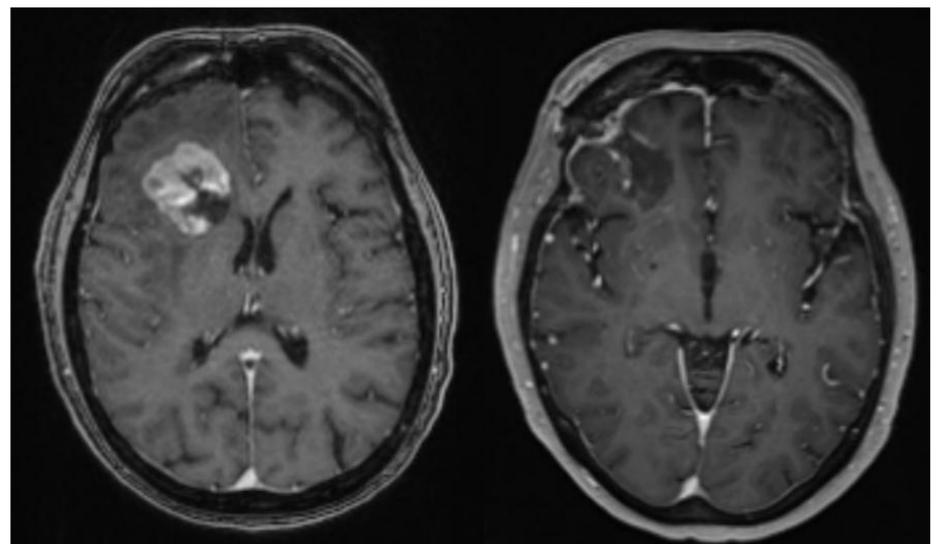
Pre- and postoperative axial T1-weighted post-contrast MRI
